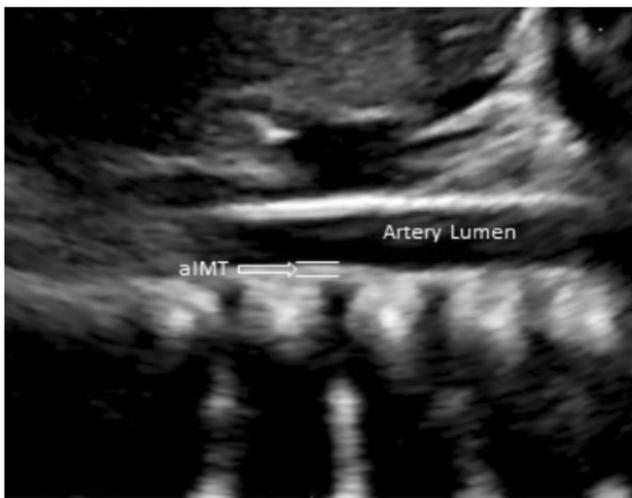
Ultrasound image of posterior wall of aorta and measurement of intima-media thickness
